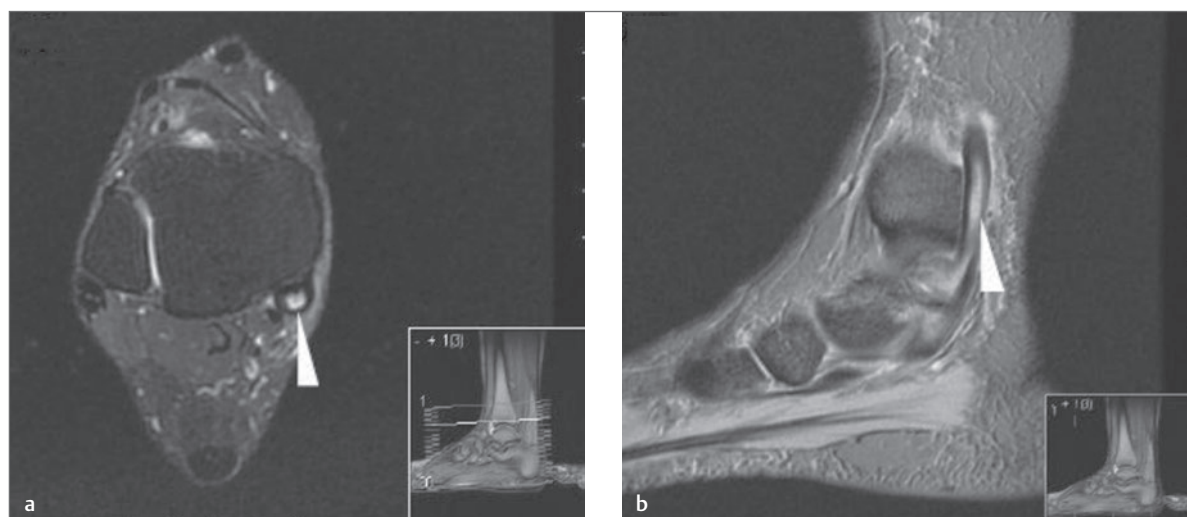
(a,b) MRI of the ankle. Axial STIR and sagittal T2, respectively, demonstrate expansion of the tibialis posterior tendon with intrasubstance high signal in keeping with a tear (*white arrowhead*). The images are of the same patient as demonstrated in ► Fig. 12.23a–c.
